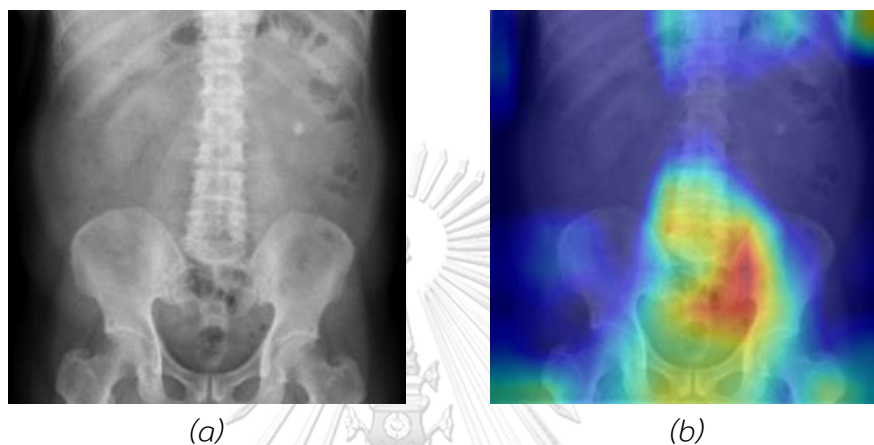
Grad-CAM on KUB radiograph: (a) original image and (b) Grad-CAM
